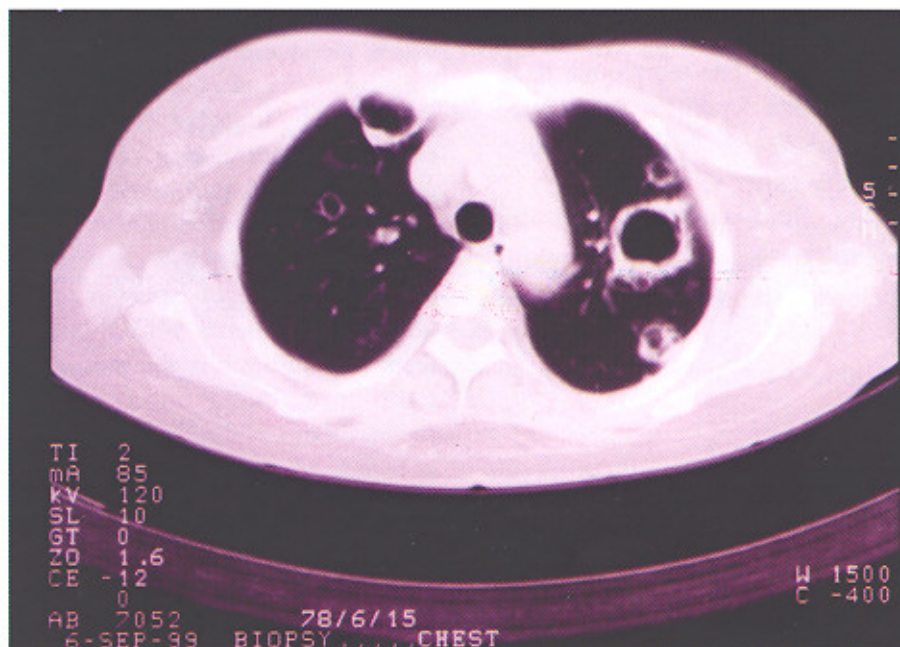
Pulmonary aspergillus was isolated in transthoracic biopsy under chest CT Scan-guided
